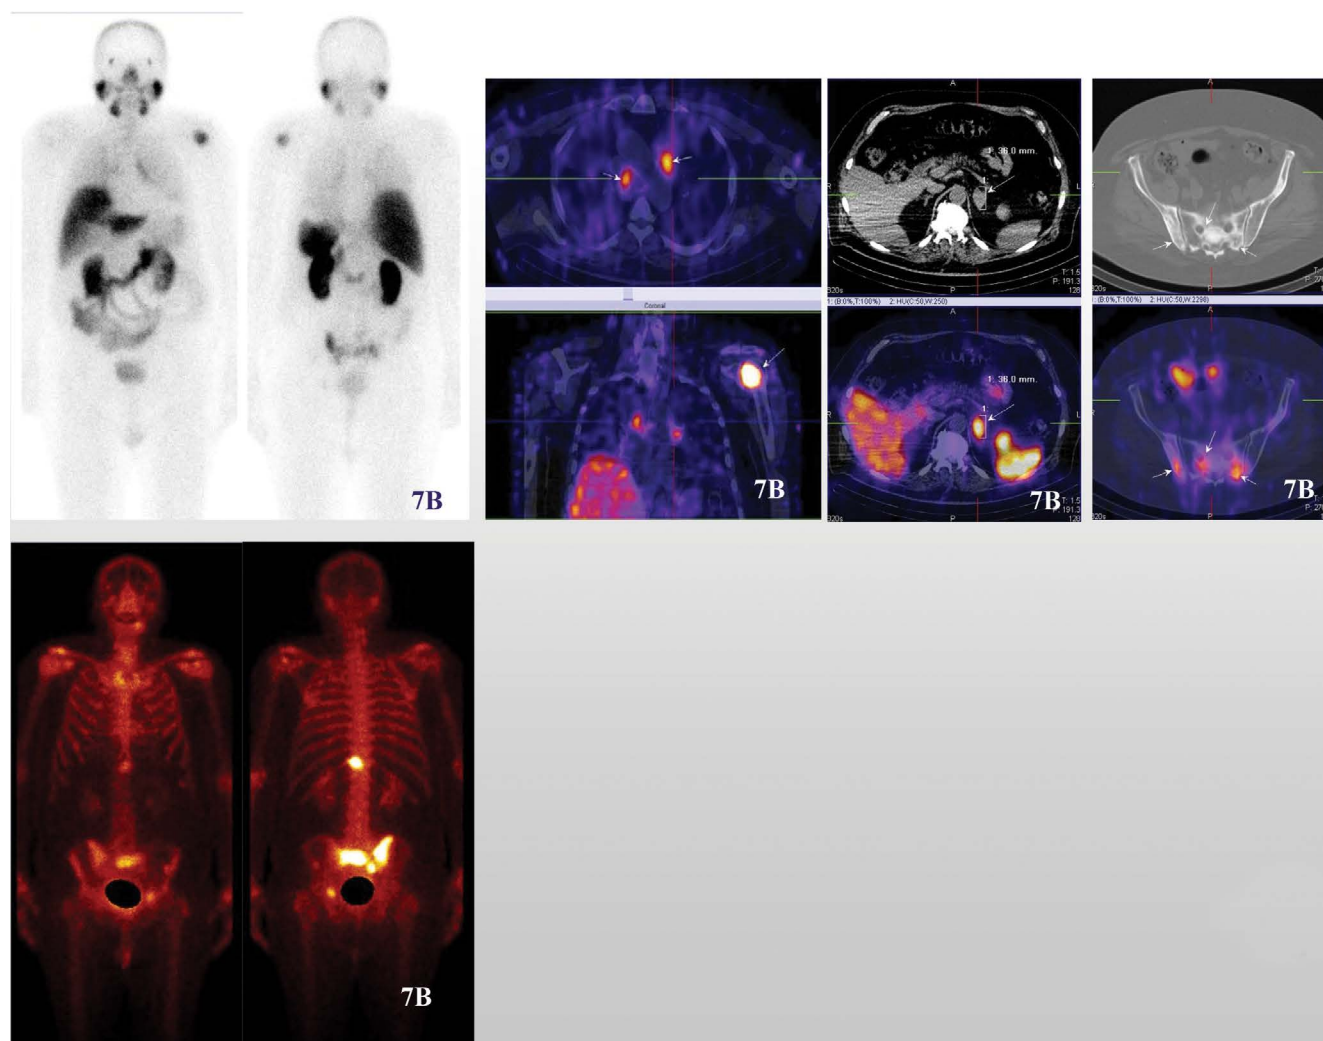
M/79yr with prostate cancer, T3N0M0, G3, GI = 10 (35 + 5). Radiotherapy (2017), androgen deprivation therapy, chemotherapy. PSA = 10.87 ng/mL (03/2019). Whole-body scan and target [^{99m}Tc]Tc-PSMA-T4 SPECT-CT imaging showed multiple osteosclerotic bone lesions, partially negative due to prior treatment; B. Bone scan performed 6 months previously with a positive result for bone metastases in the pelvis, Th12 and left shoulder. New enlarged mediastinal lymph nodes and enlarged left adrenal gland, significant for metastases, were visualized. Disease progression
